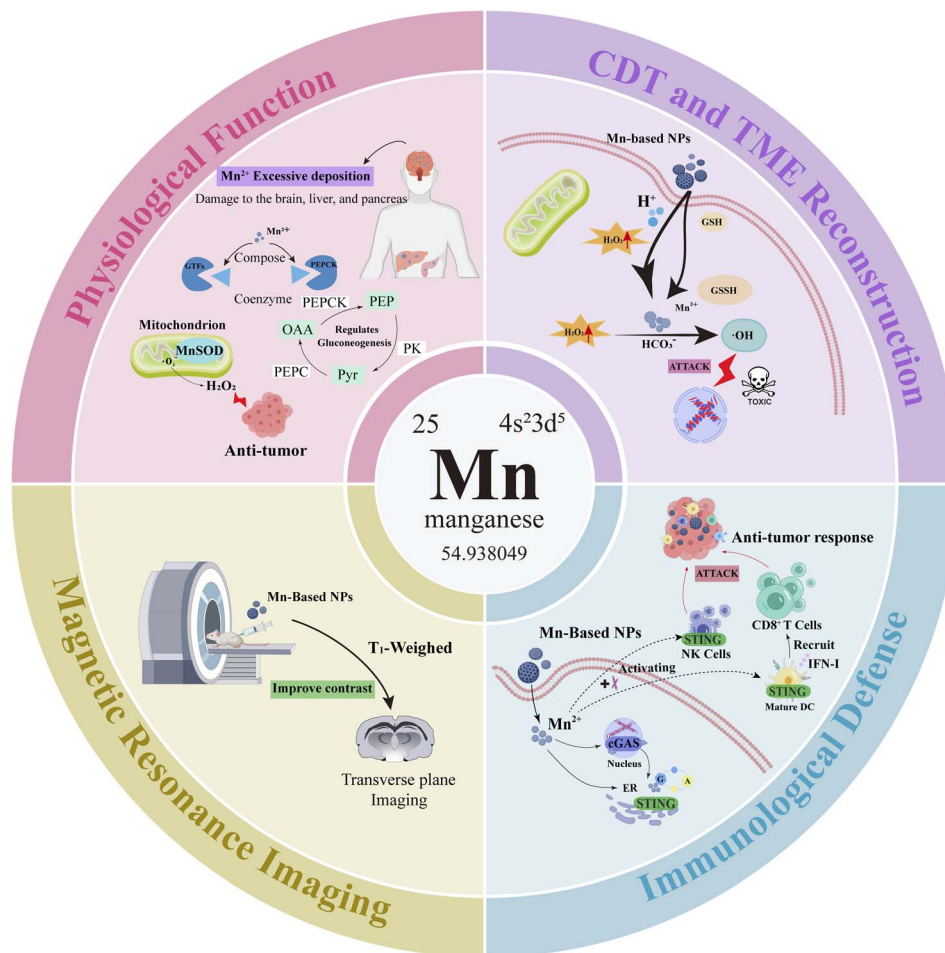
Manganese has the following four main functions: (1) physiological functions; (2) chemodynamic therapy and tumor microenvironment regulation; (3) immune defense; (4) magnetic resonance imaging.
